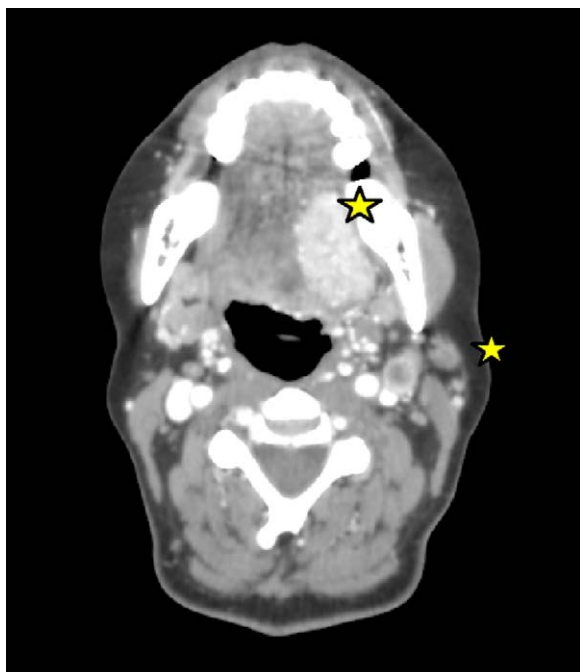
Hypervascularized metastasis to the left hemibase of the tongue, and left area II lymph node metastasis: aspect on contrast-enhanced CT.
